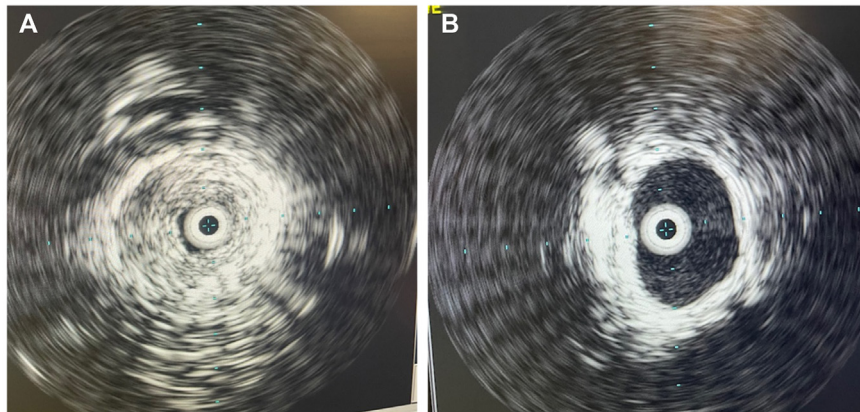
(A) Preintervention intravascular ultrasound (IVUS) showing near complete occlusion of venous stent due to in-stent restenosis (ISR). (B) Postintervention IVUS showing resolution of ISR.
